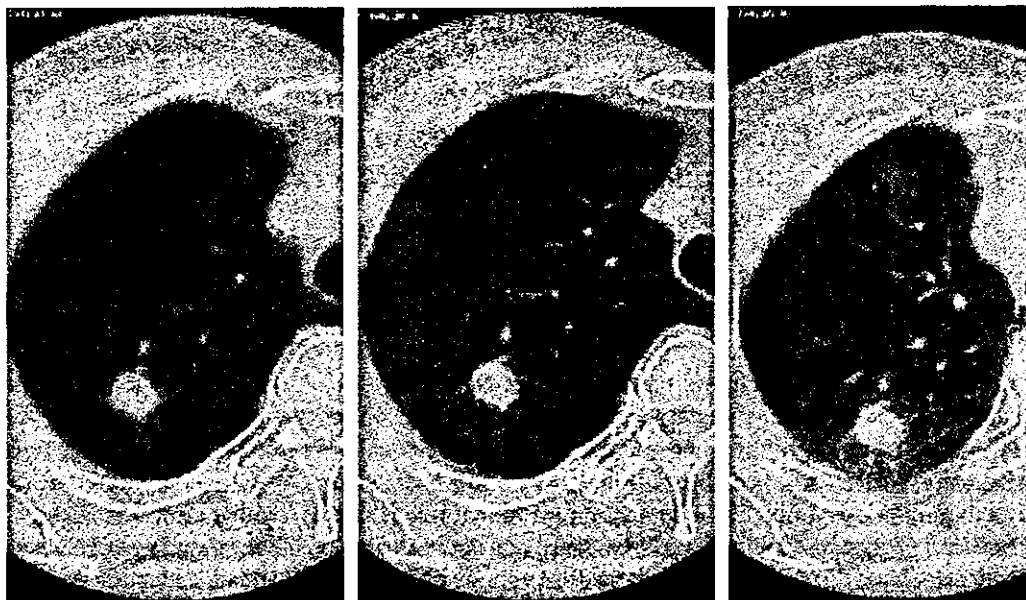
CT scans in three breathing states (from left, CT scans obtained during free breathing, inspiration breath-hold, and expiration breath-hold).
